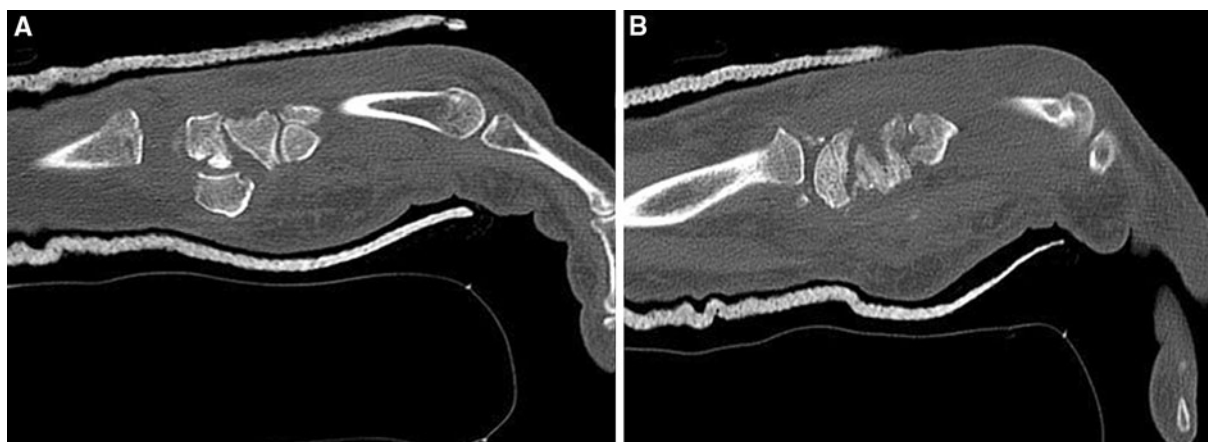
a CT scan (sagittal) non-union between triquetrum and hamate b CT scan (sagittal) non-union between lunate and capitate
